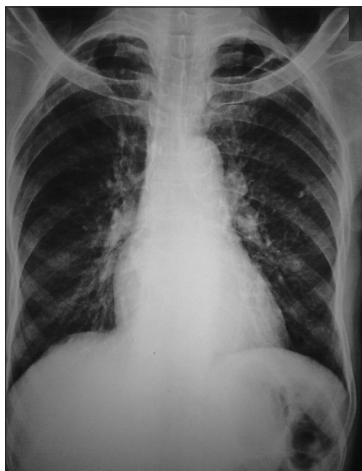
Postero-Anterior (PA) view of chest X-ray.
